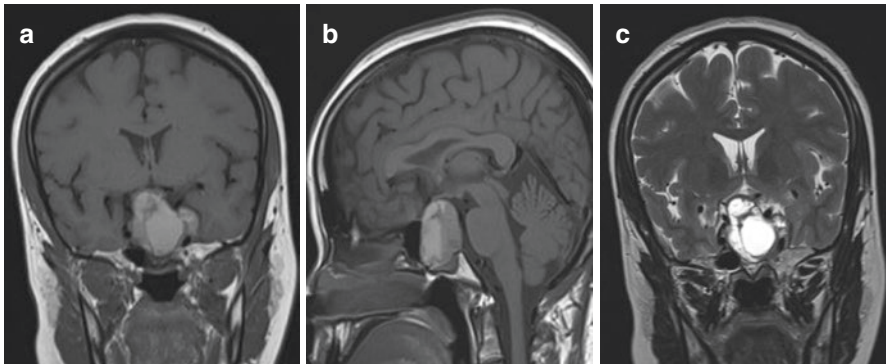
Pre-contrast enhancement coronal (a) and sagittal (b) T1-weighted magnetic resonance image (T1WI) and T2-weighted magnetic resonance image sequences. (a): Sellar, infra and supra-sellar lesion with areas of spontaneous hyperintense signal in T1WI. (b): Evidence of fluid and debris with hyperintense signal in upper layer and hypointense signal in lower layer. (c): Heterogeneous lesion with predominant areas of hyperintense signal and others of hypointense signal. These images were performed in a patient with classical sign and symptoms of pituitary apoplexy 20 days after pituitary apoplexy
